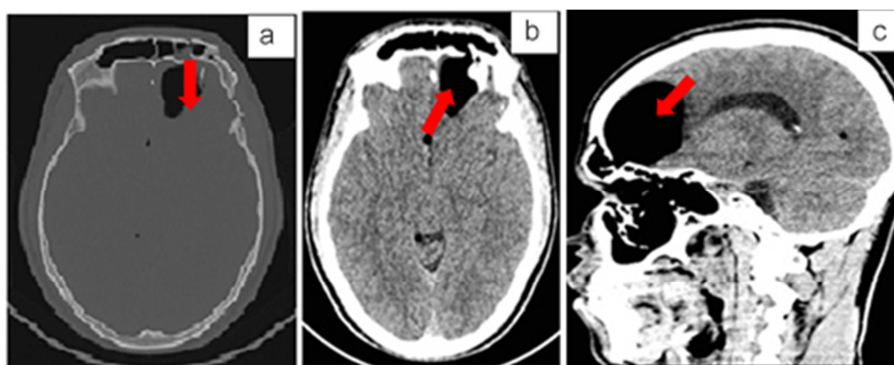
Cranioencephalic CT scan in axial section in bone window (a), axial section in parenchymal window (b), sagittal reconstruction in a parenchymal window (c) showing a fracture of the anterior and posterior walls of the left frontal sinus with compressive intradural pneumoencephaly, indicating the existence of an osteomeningeal breach.
